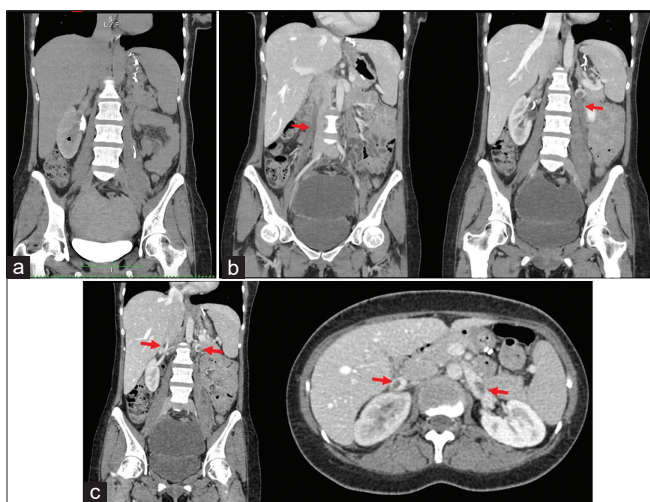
CT urography showed (a) large pelvic fluid collection, (b) bilateral gonadal veins thromboses, and (c) renal veins thromboses
